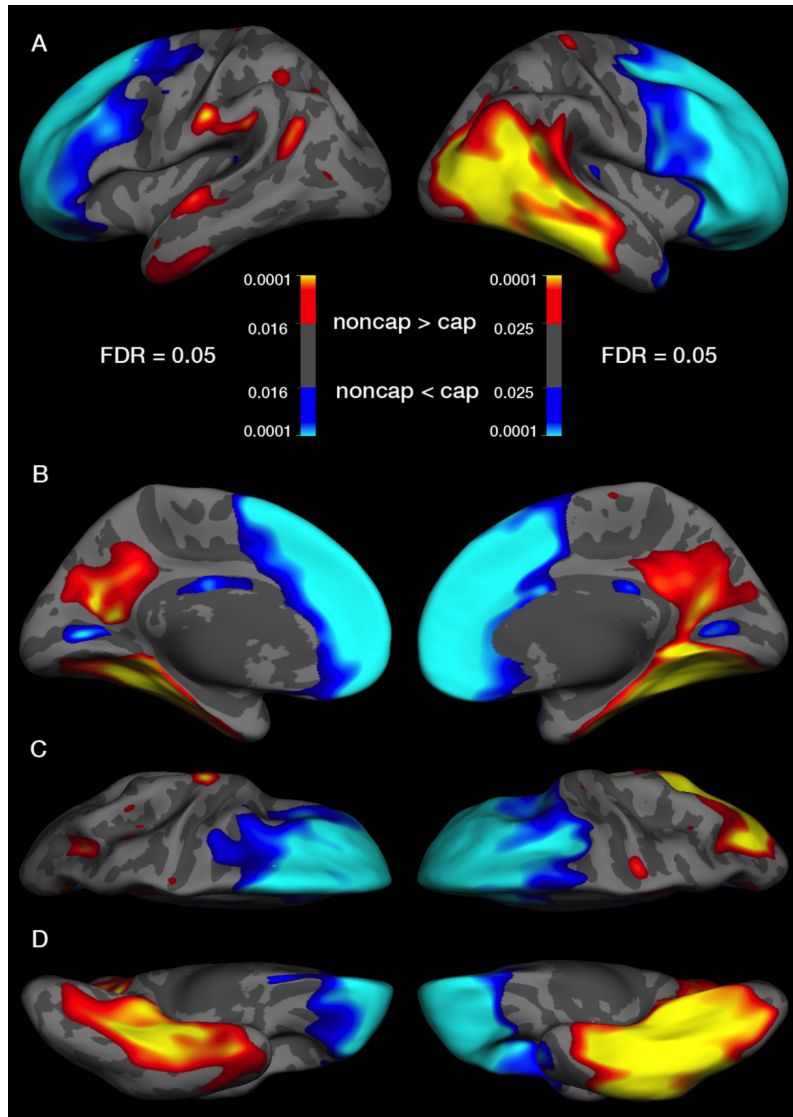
The influence of the high-density EEG net on cortical volume measurement derived from surface-based morphometry of T1-weighted images shown on A) lateral, B) medial, C) superior, and D) inferior view of the left (left column) and right (right column) hemisphere. Blue indicates an increased cortical volume over the frontal lobe when subjects do wear the EEG cap in the scanner, whereas yellow-red regions indicate a decreased cortical volume (paired t -test, FDR = 0.05). The color bar represents FDR corrected p-values.
